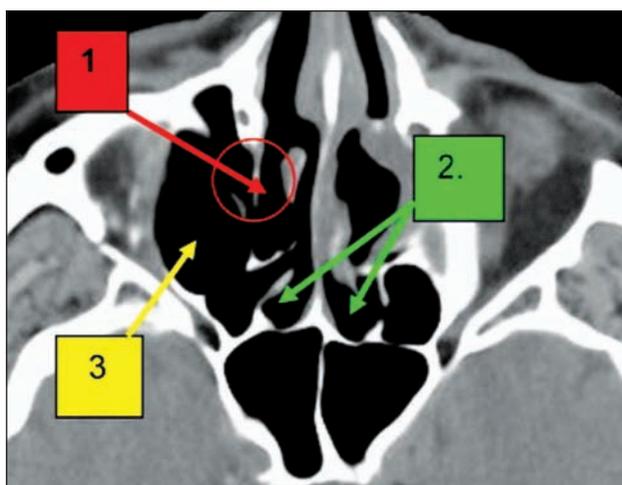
Paranasal sinuses CT scan, bone window, axial slice. 1. verticalization (lateralization) of the right uncinete process; 2. right posterior ethmoid sinus; 3. right maxillary sinus
